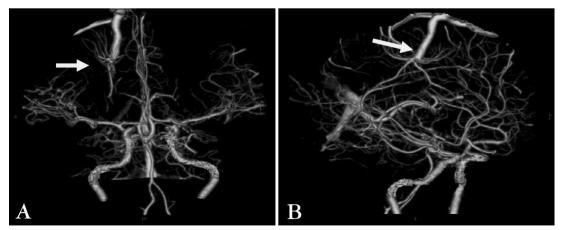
A computed tomography angiogram images showing smaller radial veins A, arrow converging on a central draining venous trunk, B arrow
